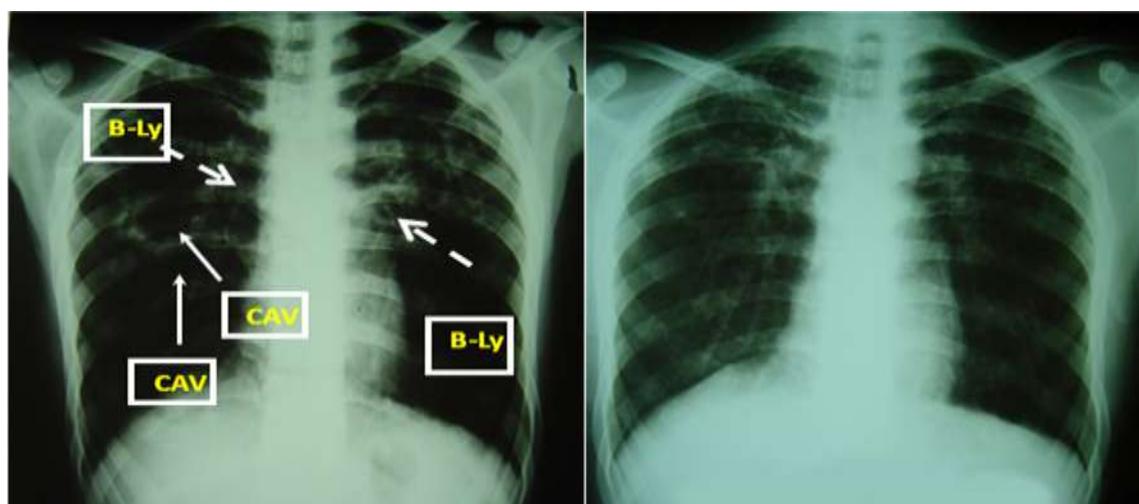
MDR-TB patient's X-ray scans before and after treatment (B-Ly: Bilateral Lymphadenopathy, CAV: Cavity)
